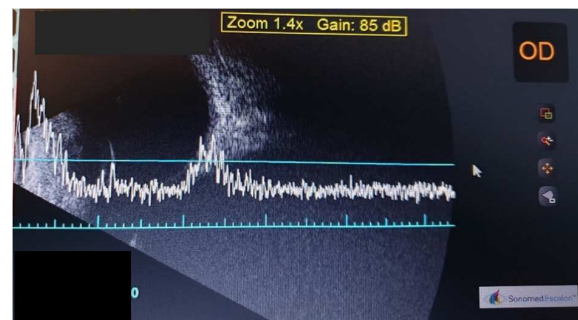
The B-scan ultrasonography of the right eye with a hyperreflective area on the optic disc corresponding with spikes on A-scan.
